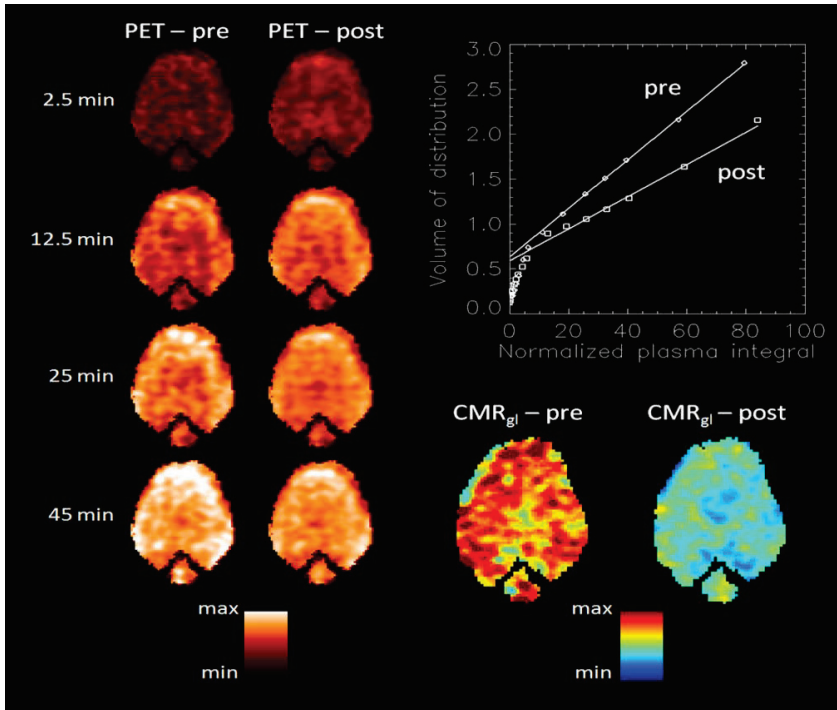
Parametric maps of increasing tissue activity over time at baseline and after hypoxia and resuscitation (left). Patlak plots for the two time points (top right) and corresponding parametric maps for CMR<sub>gl</sub> (bottom right). Colour bars indicating max and min FDG tissue activity and CMR<sub>gl</sub> respectively.
